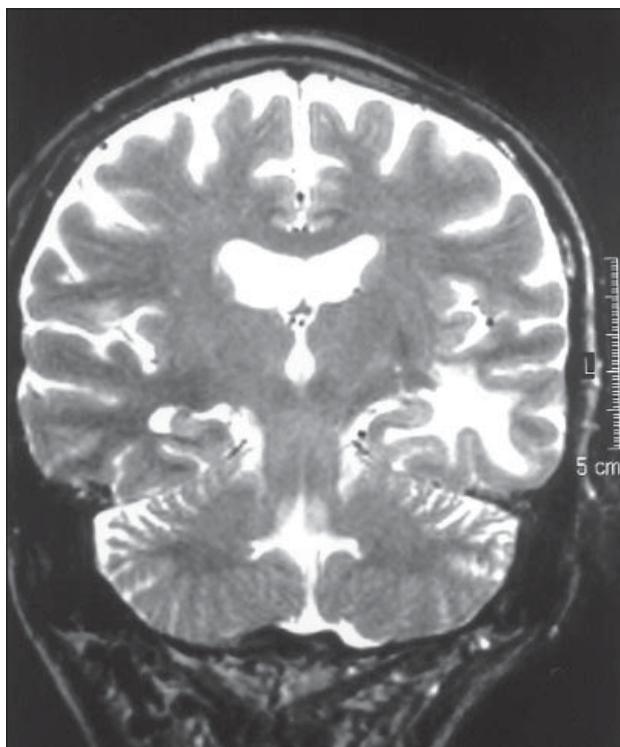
Magnetic resonance imaging showing unilateral temporal lobe necrosis.
